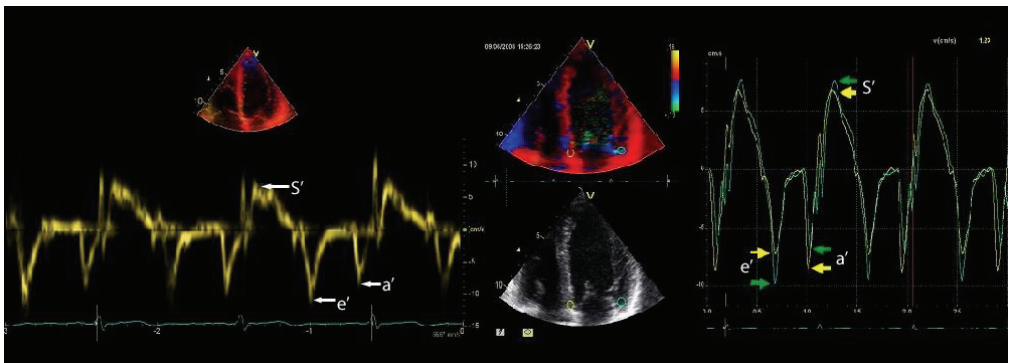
Peak systolic velocity (S'), and peak early (e') and late (a') diastolic velocities assessed by pulsed wave (left) and colour tissue Doppler (right). Left figure: Doppler curve with sample volume in the base of the inferoseptum and right figure: Yellow curve with region of interest (ROI) in the base of the inferoseptum and green curve with ROI in the base of the lateral wall.
